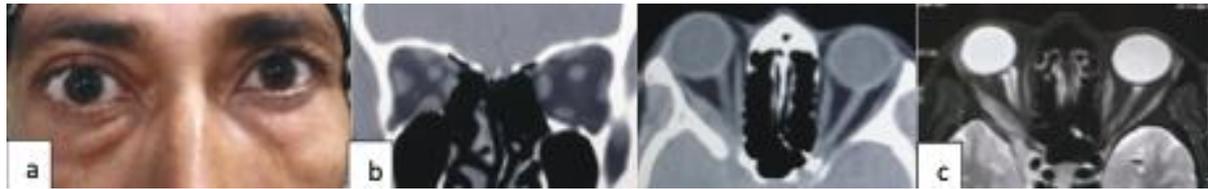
a) A 49-year-old female presented with right proptosis and ophthalmoplegia due to IOI, b) CT scan orbit coronal and axial view demonstrates rectus muscle hypertrophy with tendon involvement, c) T2 weighted MRI- Hyperintense enlarged rectus
